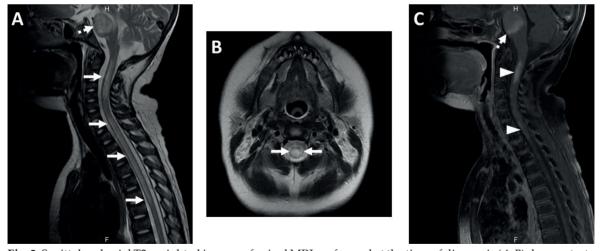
Sagittal and axial T2-weighted images of spinal MRI performed at the time of diagnosis (*A-B*) demonstrate longitudinally and transversally extensive (*arrows, A*) increased T2 signal extending from cervicomedullary junction to T7, with patchy contrast enhancement (*arrowheads, C*) on sagittal fat-suppressed T1-weighted images. In addition, note large T2 hyperintensity and contrast enhancement (*dashed arrow, A-C*) within the pons.
